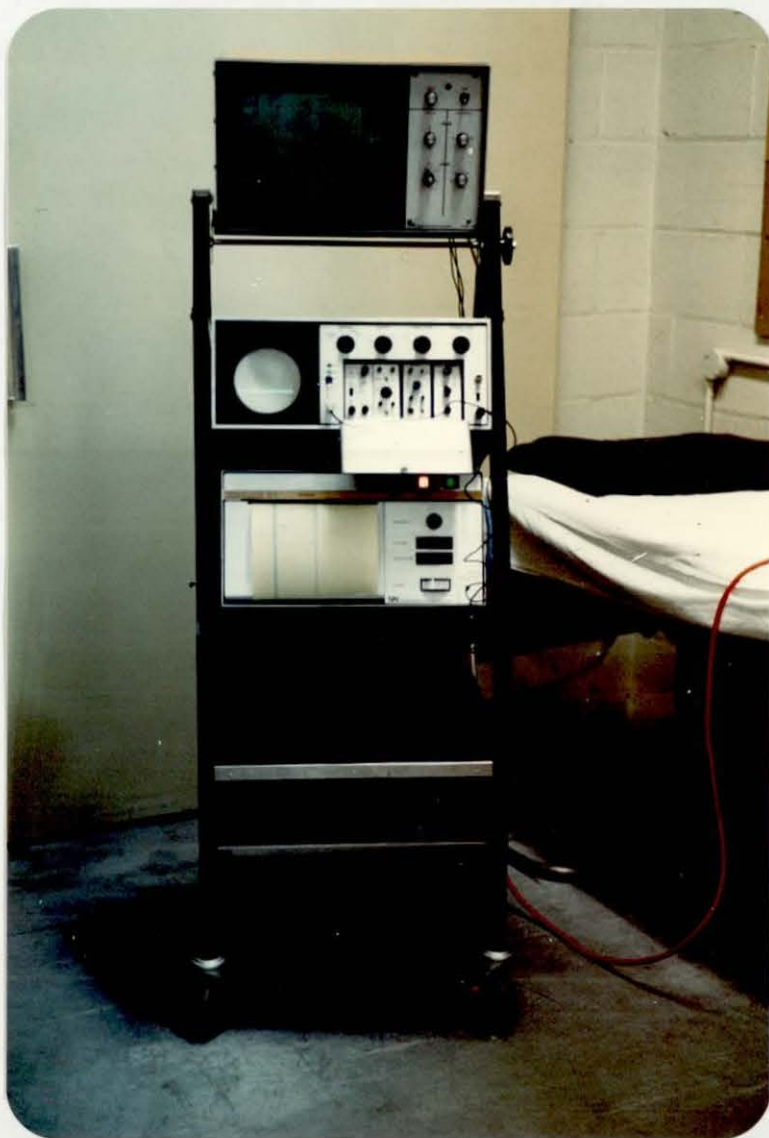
The Ekoline 20A ultrasonoscope used in this study, with the Ekoline 20A video strip chart recorder shown beneath.
